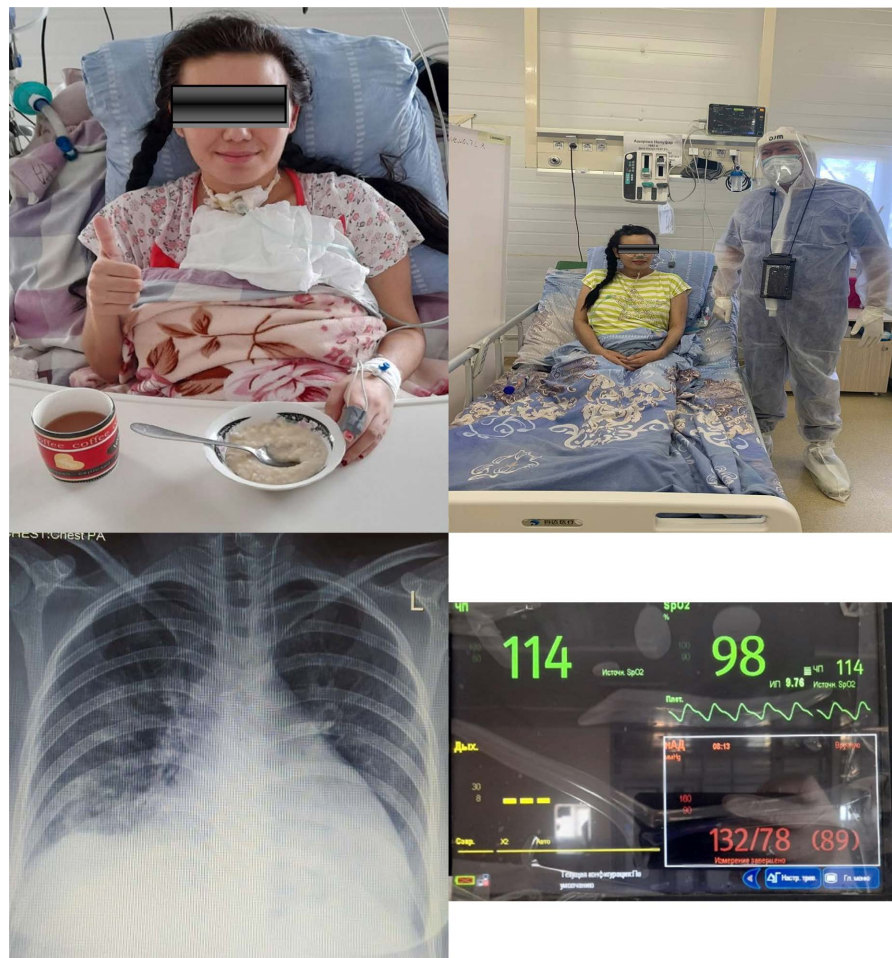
The X-ray of the lung and photo of the patient with severe COVID-19 associated ARDS and PTSD on day 17 in the ICU.
